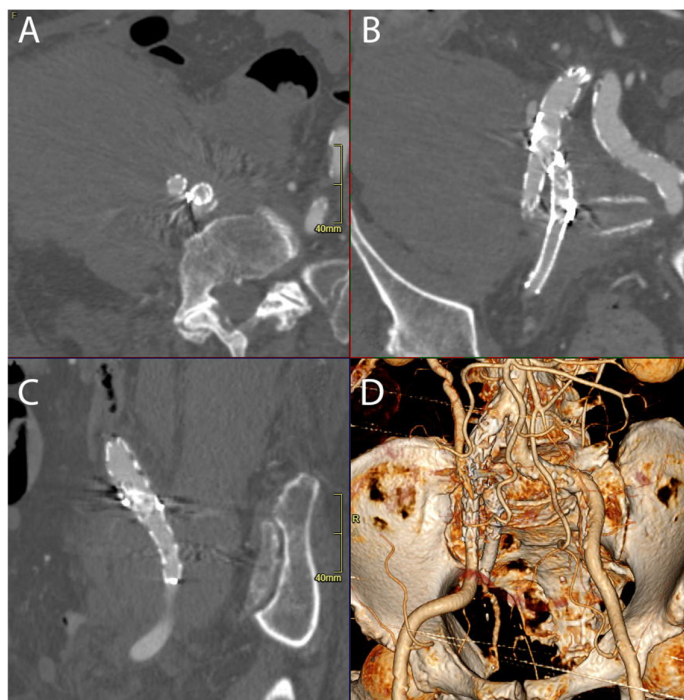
Multiplanar reformation (MPR view in axial (A), coronal (B), sagittal (C)) and 3D reconstruction (D) of postoperative CT angiography demonstrating that the endograft (Endurant II limb) extends to cover the common and external iliac arteries, along with embolization of the right internal iliac artery.
